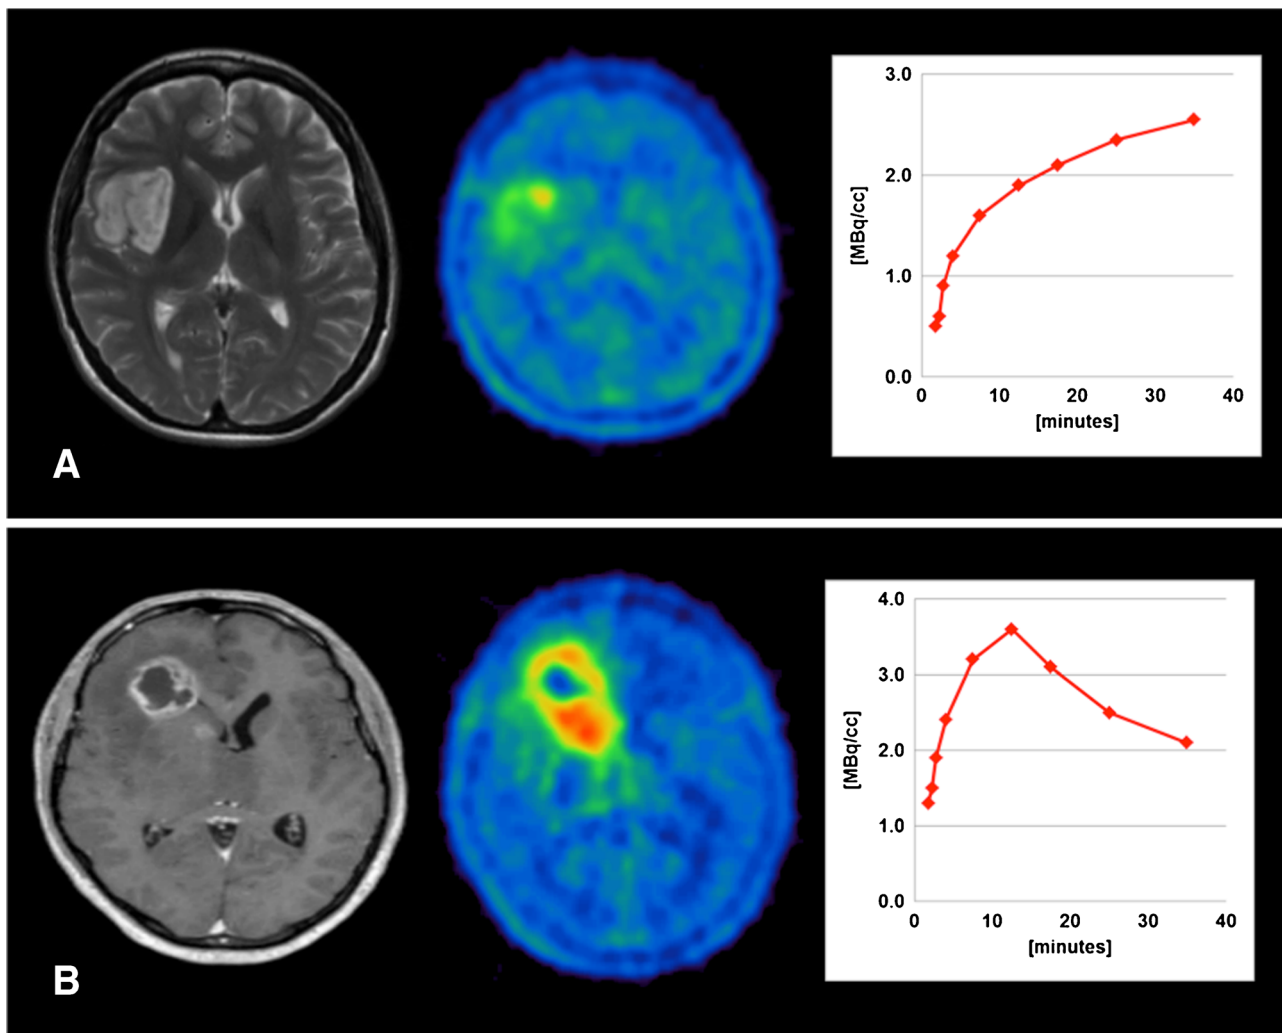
a An example of a LGG patient with a small hot-spot on ^{18}F FET-PET and “benign” increasing TAC. b A HGG patient with larger ^{18}F FET-based volume than contrast enhancement on MRI and “malignant” decreasing TAC.
